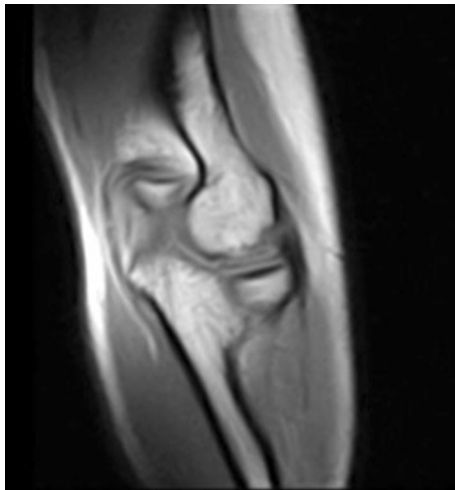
Coronal MR image showing the new M-UCL at 3 years follow-up
